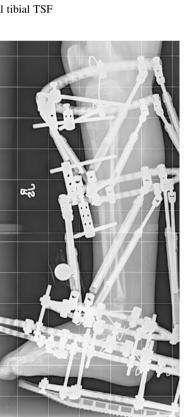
Lateral tibial X-ray: double-level TSF for proximal lengthening and distal varus correction
